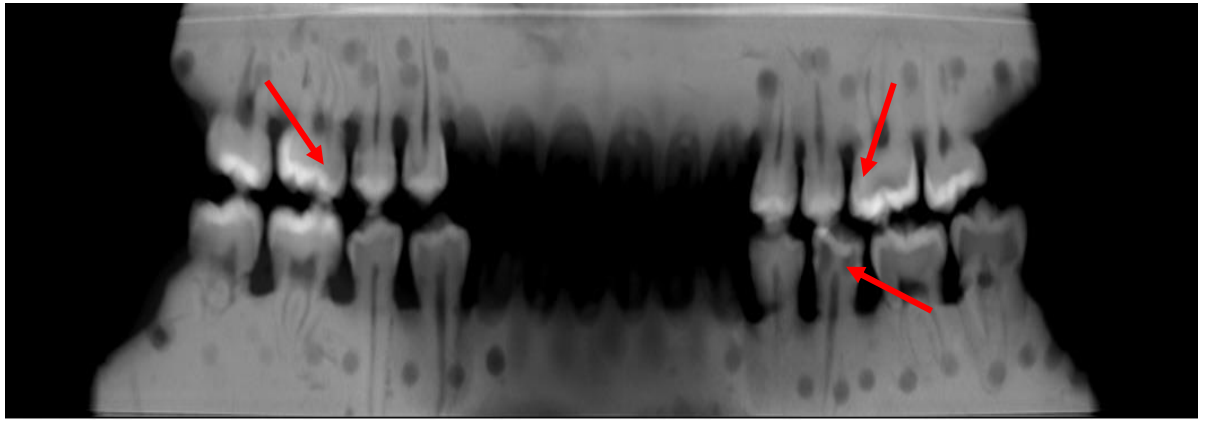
Cone beam-CT slice (panoramic 2D image) in sagittal plane showing typical occlusal and proximal lesions extending to dentine.
